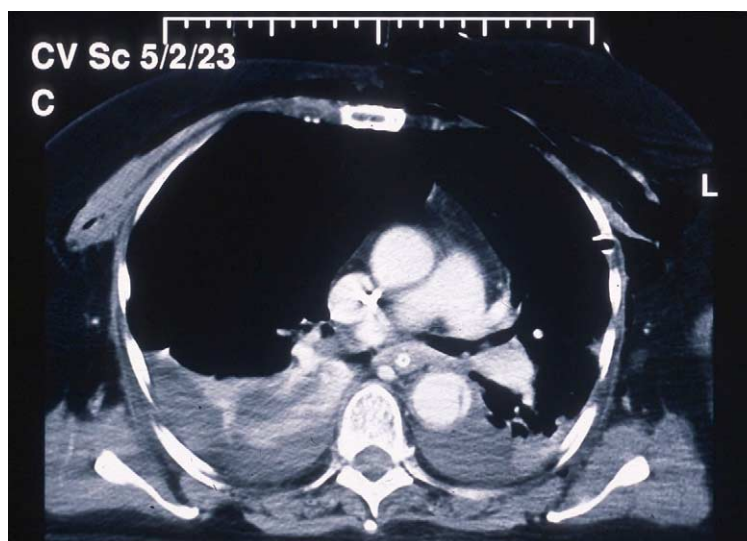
CT radiograph demonstrating aortic dissection flap and mediastinal haematoma.
